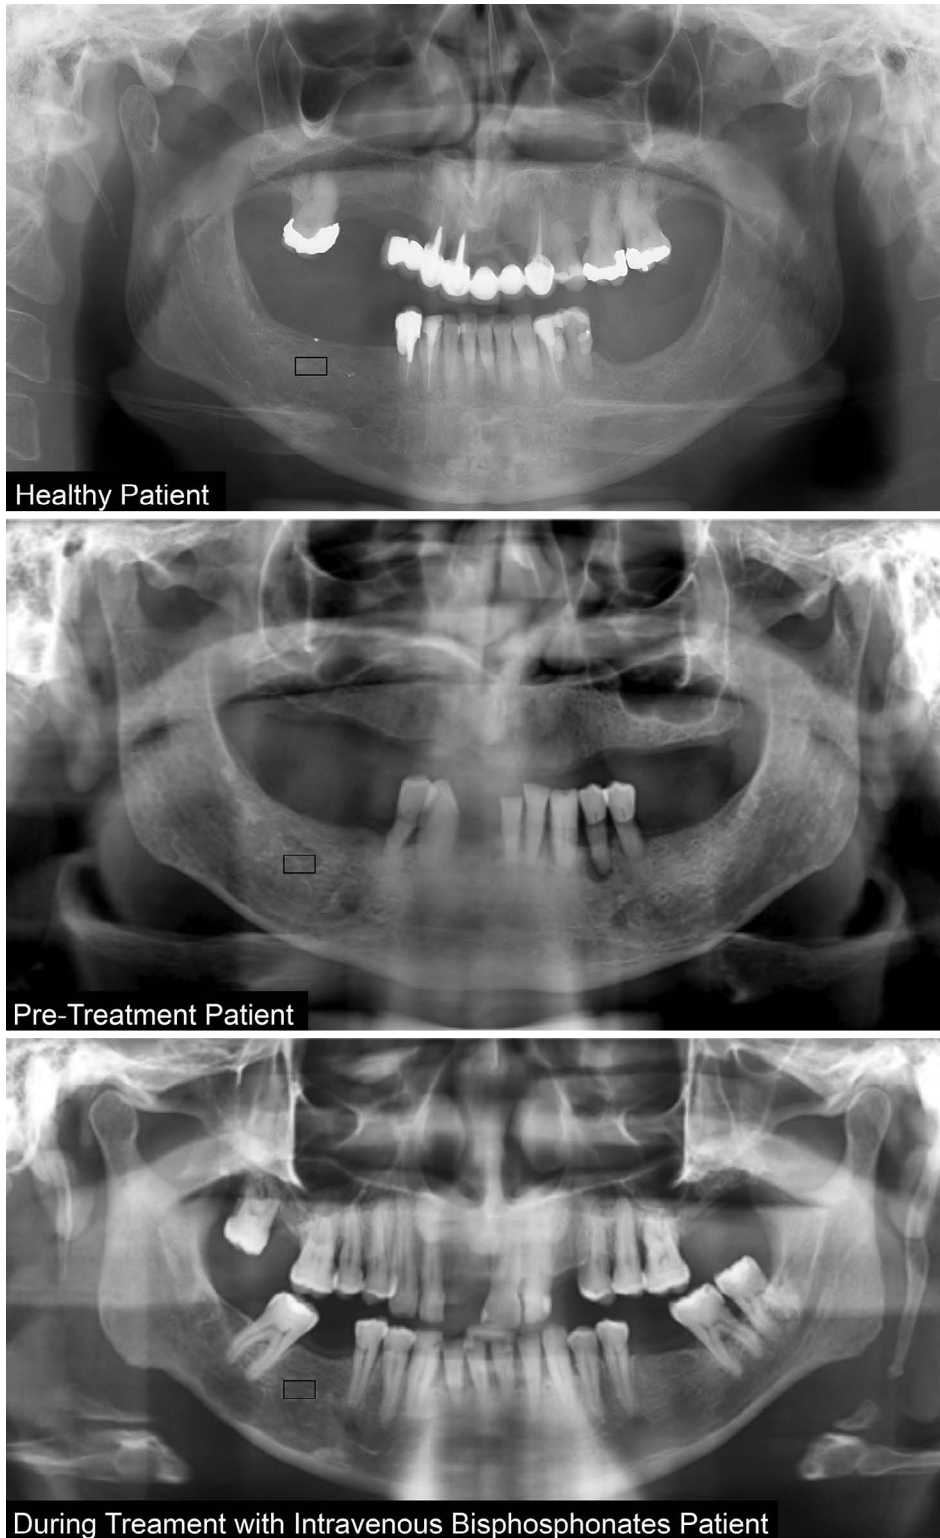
Representative panoramic radiographs with a region of interest in the right mandibular body (black rectangle) of a healthy patient, pre-treatment patient, and during intravenous bisphosphonate treatment patient, respectively. The 3 panoramic radiographs are from different patients.
